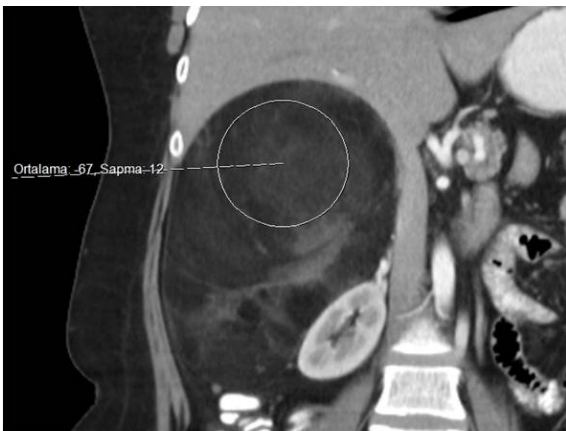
In coronal contrast-enhanced CT image; there is heterogeneous well-defined, mass covering upper right retroperitoneal space with average attenuation value of -67 HU which is consistent with fat. Fat tissue is interspersed with higher attenuation areas which are consistent with hematopoietic tissue or hemorrhage.
